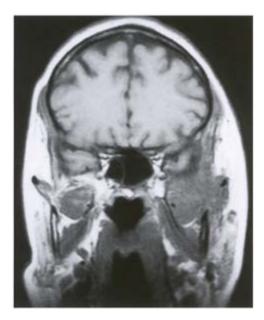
Coronal MR image of a space-occupying lesion of the infratemporal fossa which appeared like a tumour, but was caused by an inflammatory process.
